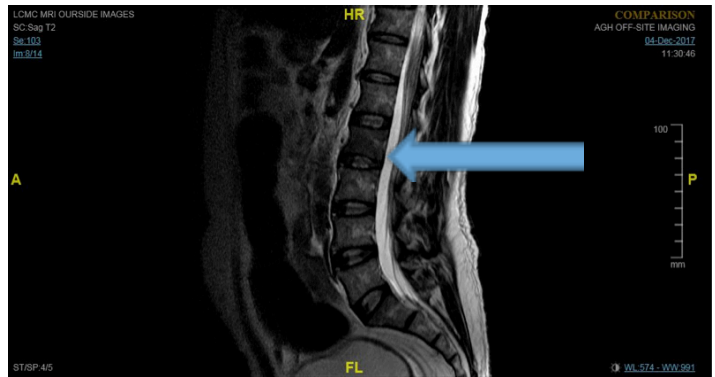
T2 weighted MRI of lumbar spine from outside hospital revealing abnormality at L2
